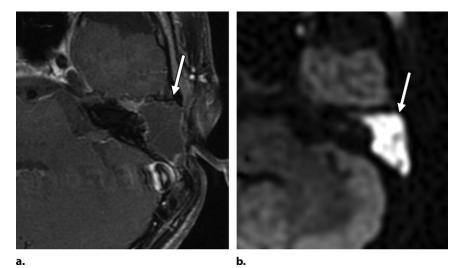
Recurrent cholesteatoma. Axial contrast-enhanced T1-weighted fat-suppressed (a) and non–echo-planar diffusion-weighted (b) MR images show a large lesion (arrow) with low signal intensity and thin peripheral enhancement (a) and restricted diffusion (b) occupying the left mastoidectomy cavity.
